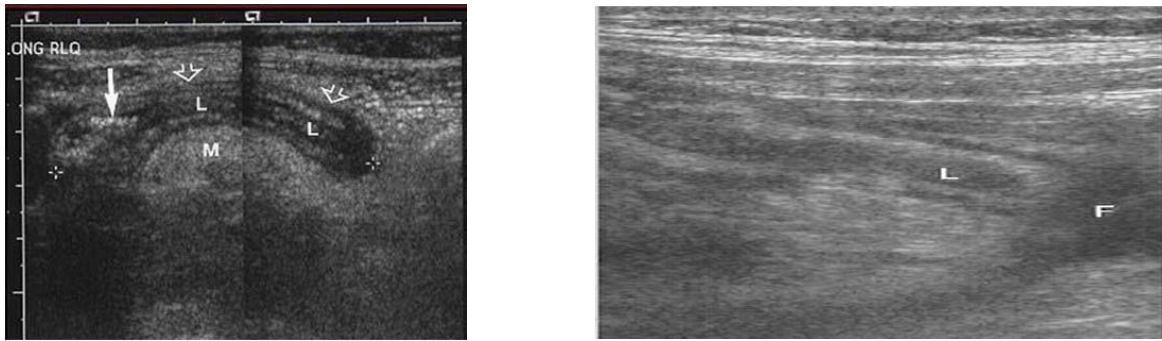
Ultrasound of the RLQ of the abdomen showing blind-ended tubular structure (open arrows) corresponding to acutely inflamed appendix. Also shown is the distended lumen [L], the echogenic surrounding mesentery [M], and the echogenic structure with acoustic shadow (arrow) at the base of the appendix corresponding to an appendolith.
